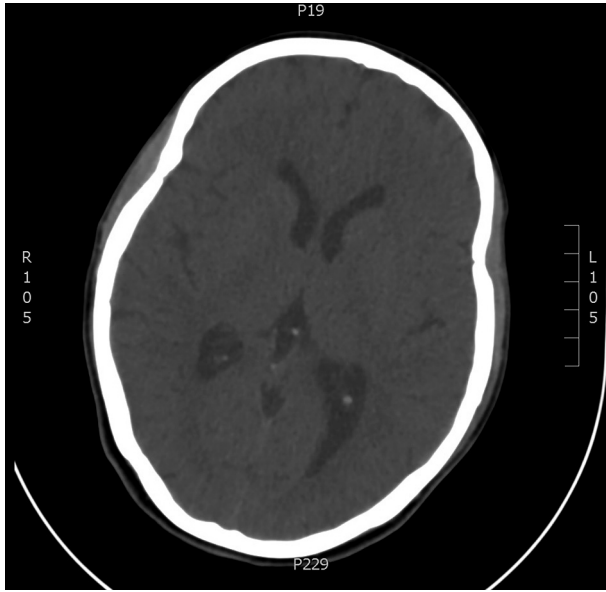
Normal computed tomography image after syncope (examination with no contrast)
